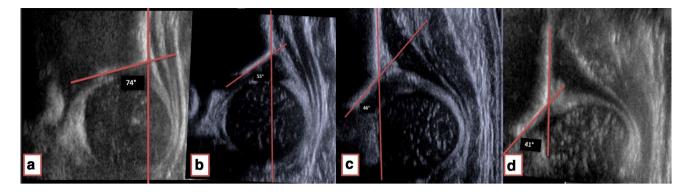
Representative images of the 4 different Graf Ultrasound grades (a = Graf I, b = Graf II, c = Graf III, d = Graf IV)
